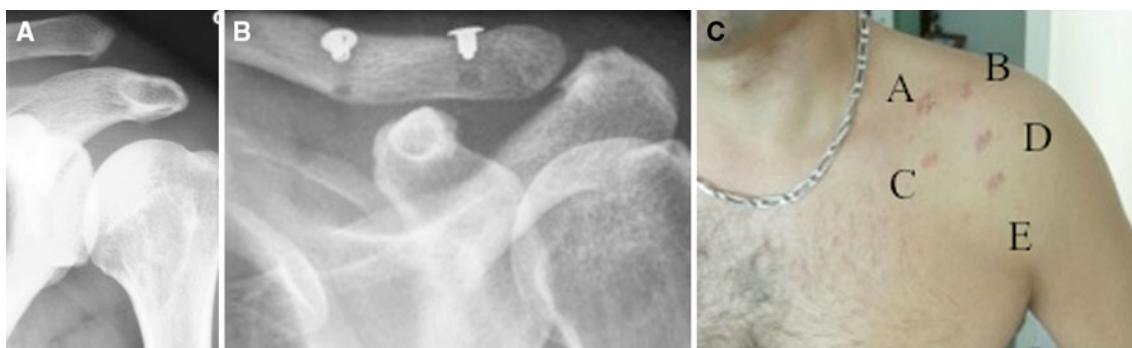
a Rockwood type III AC injury in a left shoulder. b Post-surgery follow-up X-ray 9 months. c Healed portals (A, B, C, D and E) and good cosmetic result
